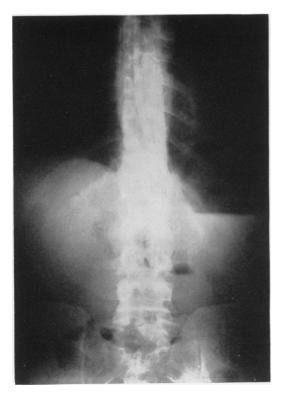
(Case 2) X-ray of abdomen taken on admission revealed a pyloric or proximal small bowel obstruction with massively distended stomach.
